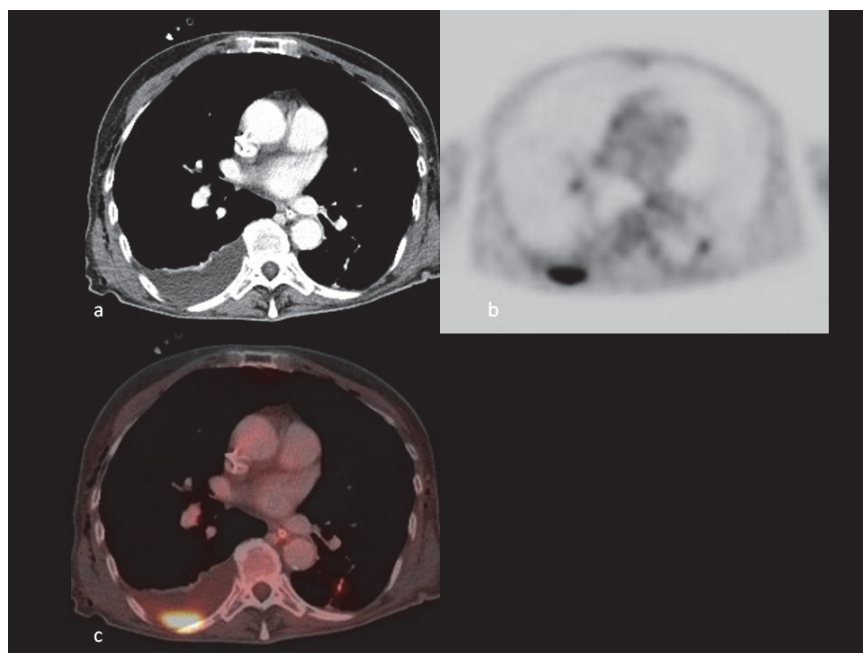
A 74-year-old woman with an abdominal tumor. CT showed a pleural effusion in the right hemi-thorax (fig 1a). CT could not demonstrate contrast-captated pleural lesions suspect for pleural metastases. PET demonstrates FDG-uptake in the dorsal part of the right hemi-thorax (fig 1b). Integrated PET/CT localizes this FDG-uptake in the pleura, indicating pleural metastases. This was confirmed after pleuroscopy.
